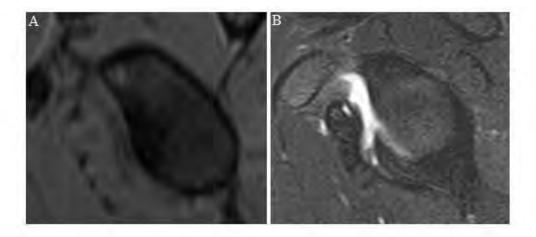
Clinical demonstration of a sagital *en face* MRI obtained prior to any instability event (A)
